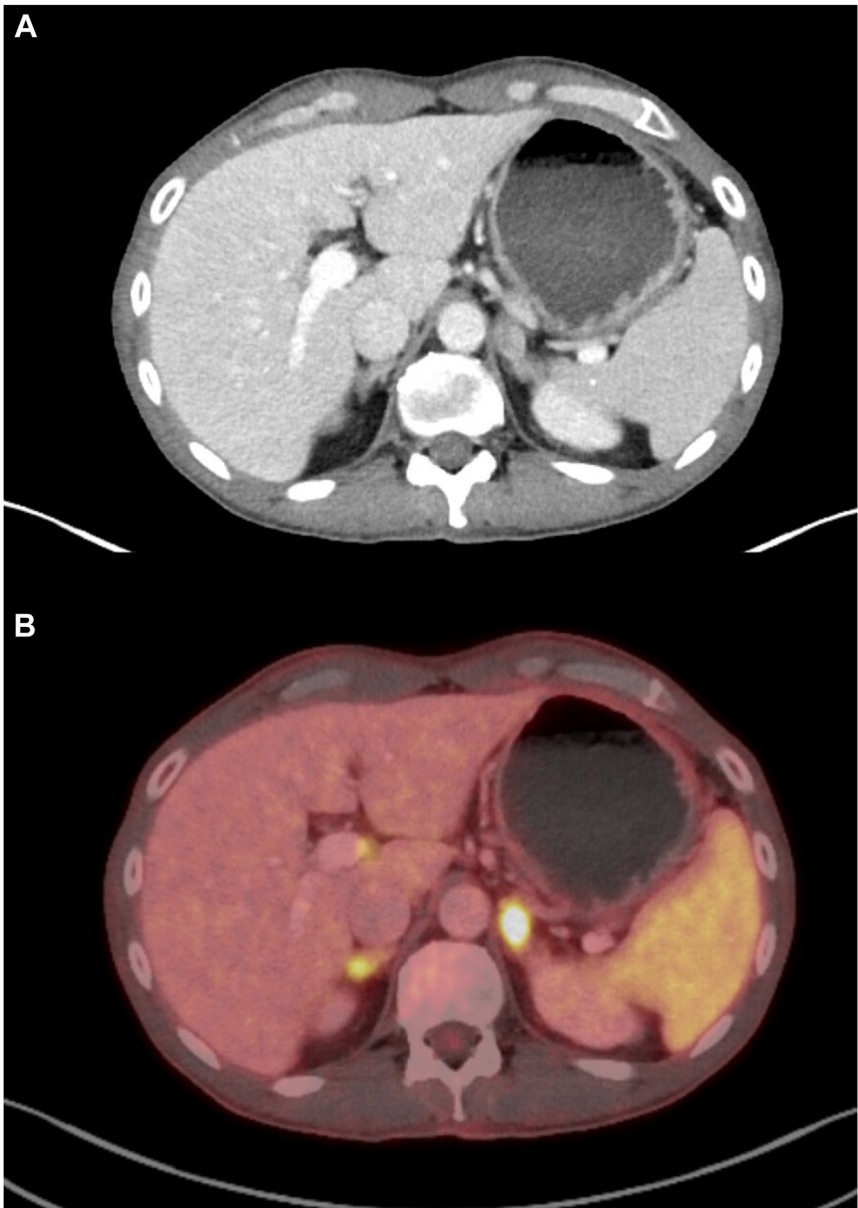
Postchemotherapy cross-sectional imaging for patient B demonstrating bilateral adrenal nodules. A, Right adrenal nodule measuring 1.0 × 0.9 cm and left adrenal nodule measuring 1.9 × 1.1 cm. B, Positron emission tomography/computed tomography demonstrating fluorodeoxyglucose-avid bilateral adrenal nodules.
